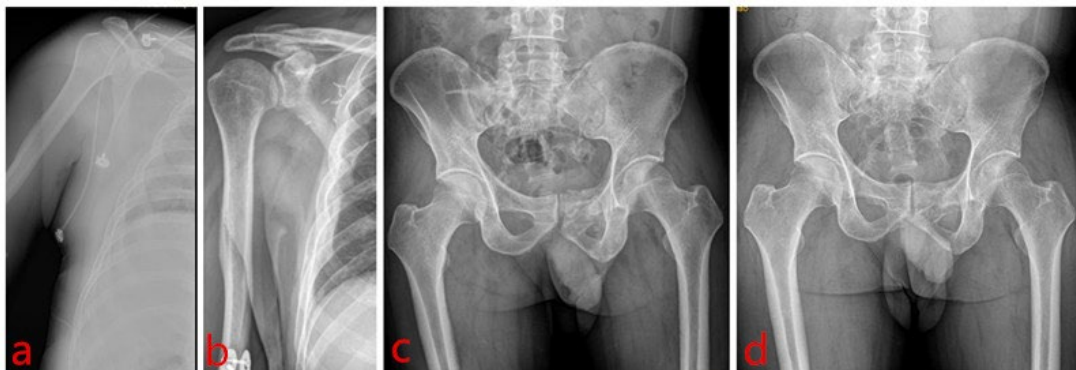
a. X-ray showed discontinuity of bone cortex in the shoulder peak segment of the right clavicle; b. X-ray reexamination 3 months after discharge showed callus formation at the fracture end; c. X-ray showed interruption of bone cortex continuity in the superior and inferior left pubic rami, surrounded by multiple free fragments; d. X-ray reexamination 3 months after discharge showed improvement of the left pubic bone, with intact bone structure.
